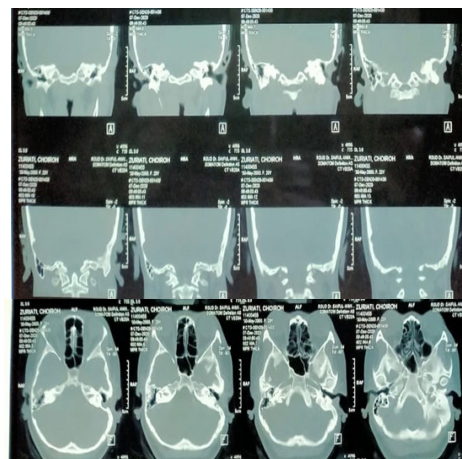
Mastoid HRCT: no visible ossicles, with isodense lesions in the mesotympanum, suspected cholesteatoma
